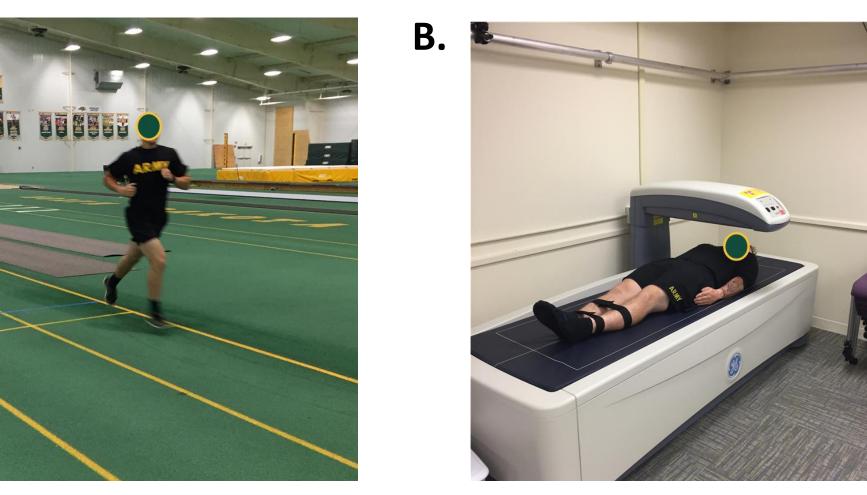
Data Collection using 3-min all-out exercise test (A) and dual-energy X-ray (B)
